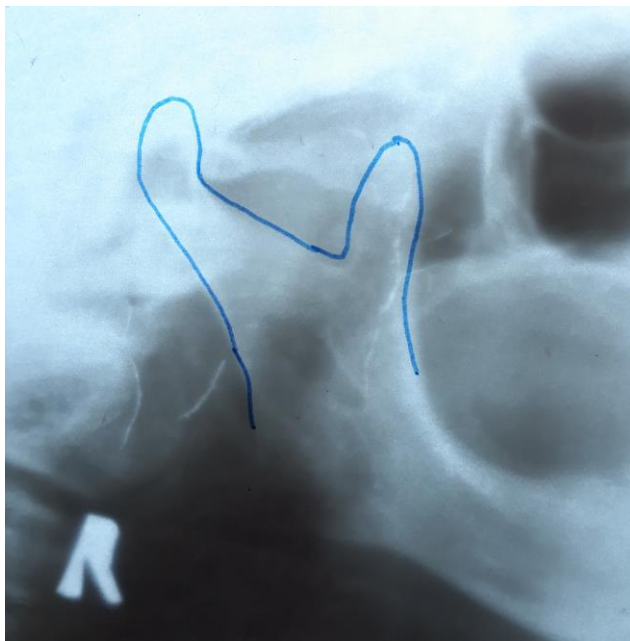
Orthopantomogram showing bilateral round condylar process with sloping sigmoid notch in right side and round sigmoid notch on left side.
